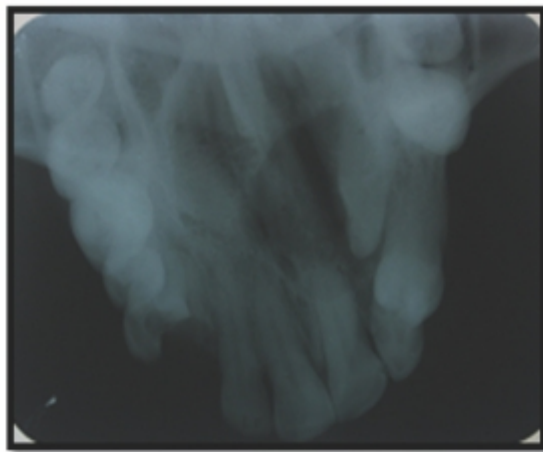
Bitewing radiograph showing lesion and impacted tooth
